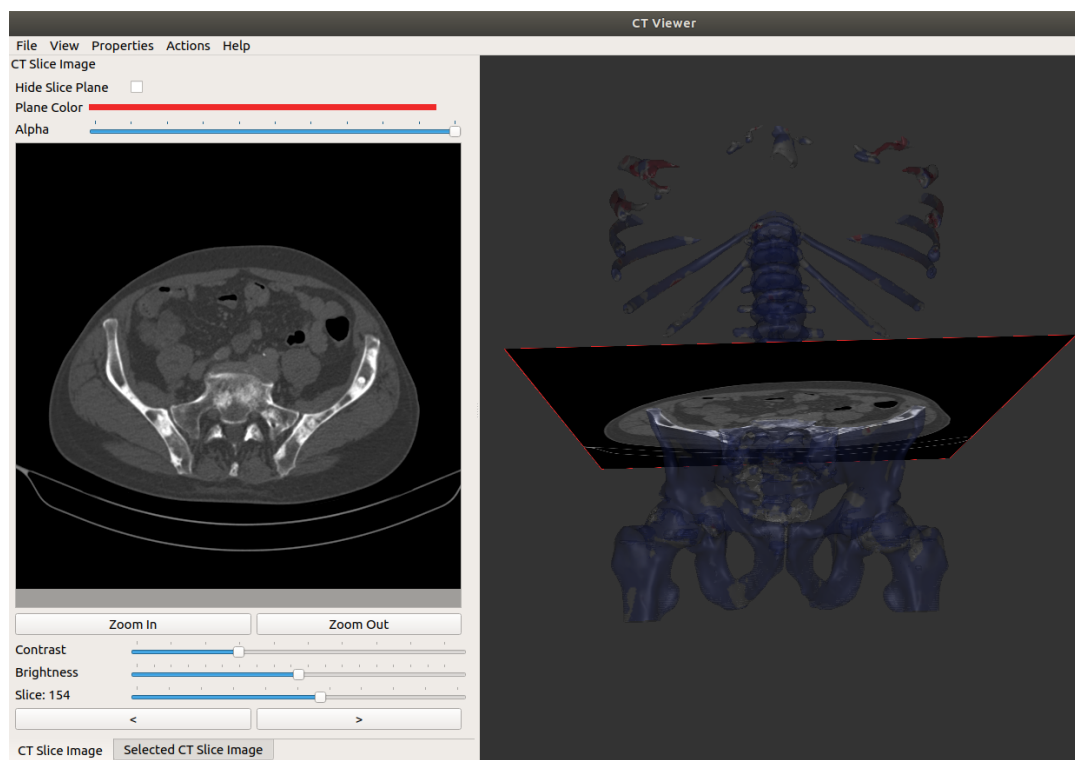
An example of the custom image viewer. The right side of the image shows the main viewer with an alpha blend applied. This blends the polygonal mesh with the background and CT slice (texture mapped) image. The left side shows the CT slice 2D along with some of the user interface controls. This allows a user to specify the display options including the alpha blend, image brightness, image contrast, image zoom and slice image selection.
